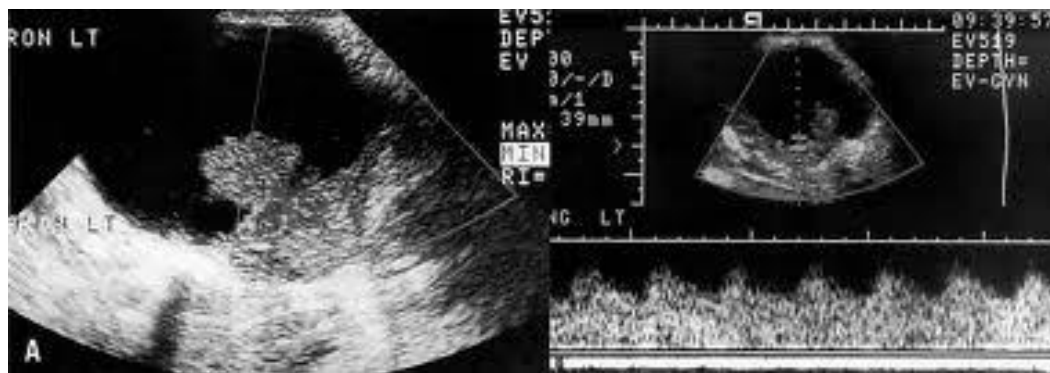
B mode and Spectral Doppler images of malignant ovarian cystic lesion shows low resistive and pulsatility indices.
